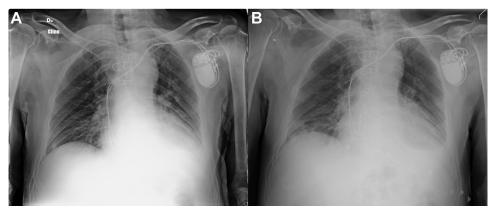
A: Unremarkable chest radiograph at the time of hospital admission. B: Chest radiograph showing right lower lobe pneumonia after hospitalization.
